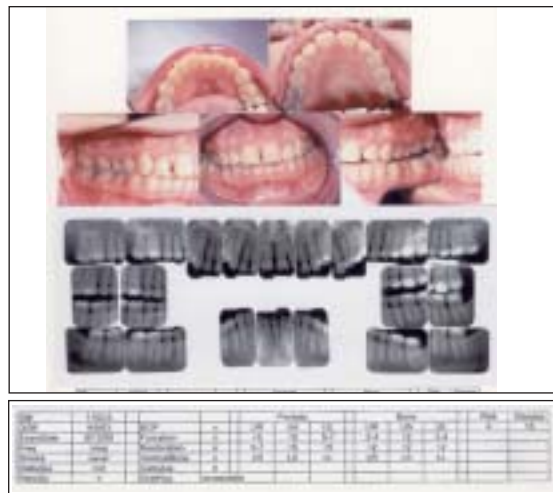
Clinical and radiographic features of a case of generalized, beginning or moderate periodontitis having a risk score of 4 and a disease score of 15.
